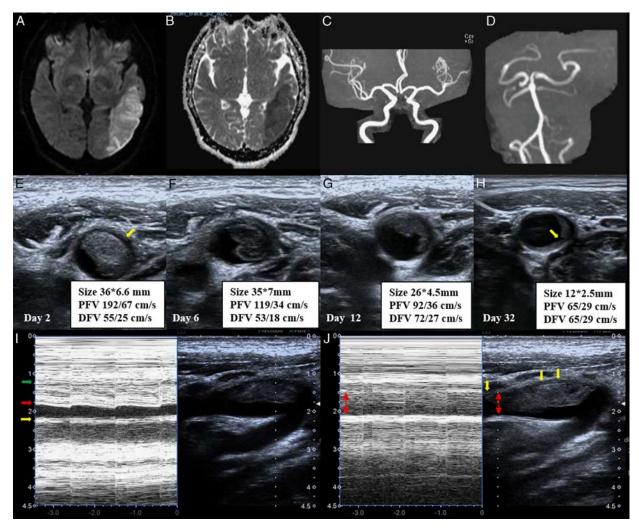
A, Diffusion weighted imaging. B, Apparent diffusion coefficient. C and D, Magnetic resonance angiography. E–H, Free-floating thrombus changes detected by duplex ultrasound. The space between intact intima and thrombosis (yellow arrow in E), tiny ulcer of the residual plaque (yellow arrow in H). I, Motion of thrombus at proximal. Motion of thrombus near the vascular wall at proximal was more weaken compared with the motion of thrombus free in the vascular, and was almost the same with vessel wall as the arrows show. J, Motion of thrombus at proximal and distal was in consistent with blood flow, intima-media thickness can be seen at axial and longitudinal view of carotid artery as the yellow arrows show. DFV indicates distal flow velocity; PFV, proximal flow velocity.
